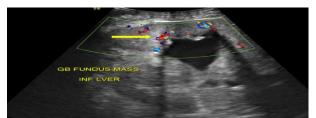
USG image showing large hetero echoic mass lesion (yellow arrow) in GB fossa with increased vascularity on color Doppler study.
